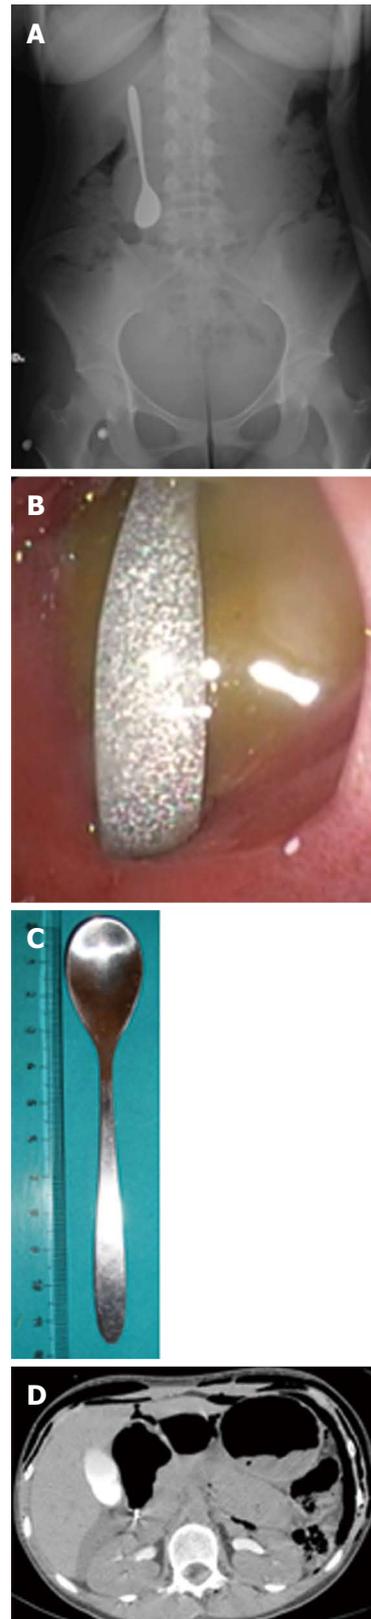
Endoscopic retrieval of a duodenal perforating teaspoon. A: Plain abdominal X-ray showing the teaspoon in the right upper abdominal quadrant. Note the absence of free intra-abdominal air; B: The tip of the teaspoon handle impacted into the duodenal mucosa at the level of the superior duodenal genu; C: The spoon after extraction: 12 cm long, 2 cm large at the cup and 0.5 cm at the handle; D: Urgent computed tomography scan showing diffuse bilateral retro-pneumoperitoneum extending to the right inguinal region, with a small amount of fluid into the retro-duodenal region near the right kidney.
